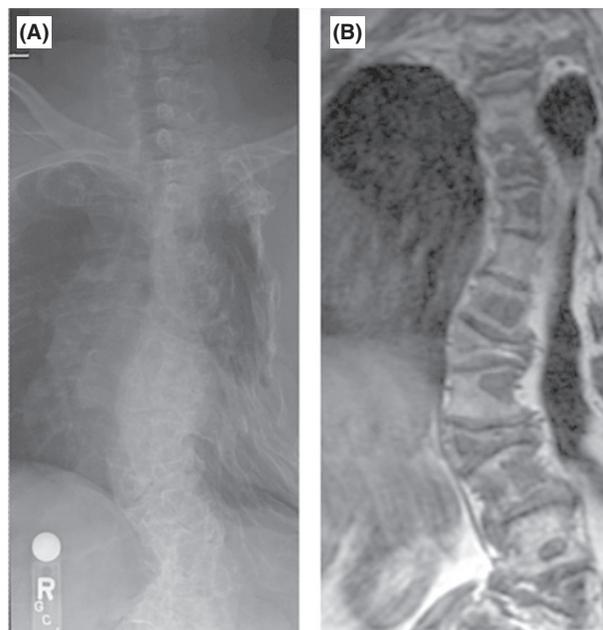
Scoliosis in FD.* Scoliosis of the spine is demonstrated in an x-ray (A) and MRI of the spine (B) in a 54-year-old woman with FD. The extent of the involvement of the vertebral columns with FD is demonstrated in the MRI where large parts of the vertebrae are shown to be replaced with FD. Surprisingly, and typically, the woman had neither pain nor any evidence of neurological compromise, despite extensive disease and multiple compression fractures.
